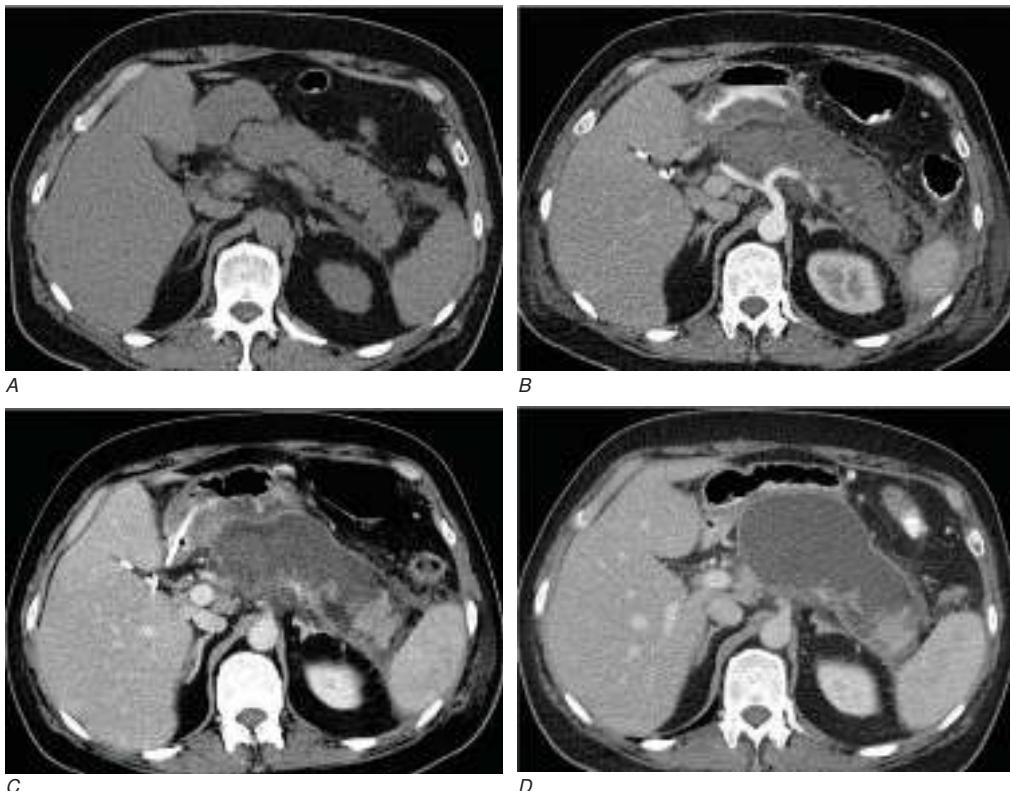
Evolution of changes of acute necrotizing pancreatitis on computed tomography (CT). A. CT scan of the abdomen without IV contrast performed on admission for a patient with acute gallstone pancreatitis, showing mild peripancreatic stranding. B. Contrast-enhanced CT scan of the abdomen performed on the same patient 1 week after admission shows extensive intrapancreatic necrosis, evidenced by the lack of contrast enhancement in the pancreatic body with very minimal enhancement noted at the distal most aspect of the pancreatic tail. C. Contrast-enhanced CT scan of the abdomen performed on the same patient 2 weeks after admission demonstrates a semiorganized, heterogeneous fluid collection, referred to as an acute necrotic collection. On this image, a small area of viable pancreatic parenchyma is seen at the tail of the pancreas. D. Contrast-enhanced CT scan of the abdomen performed on the same patient 5 weeks after admission demonstrates a well-encapsulated fluid collection, essentially replacing the pancreas, referred to as walled-off necrosis.
